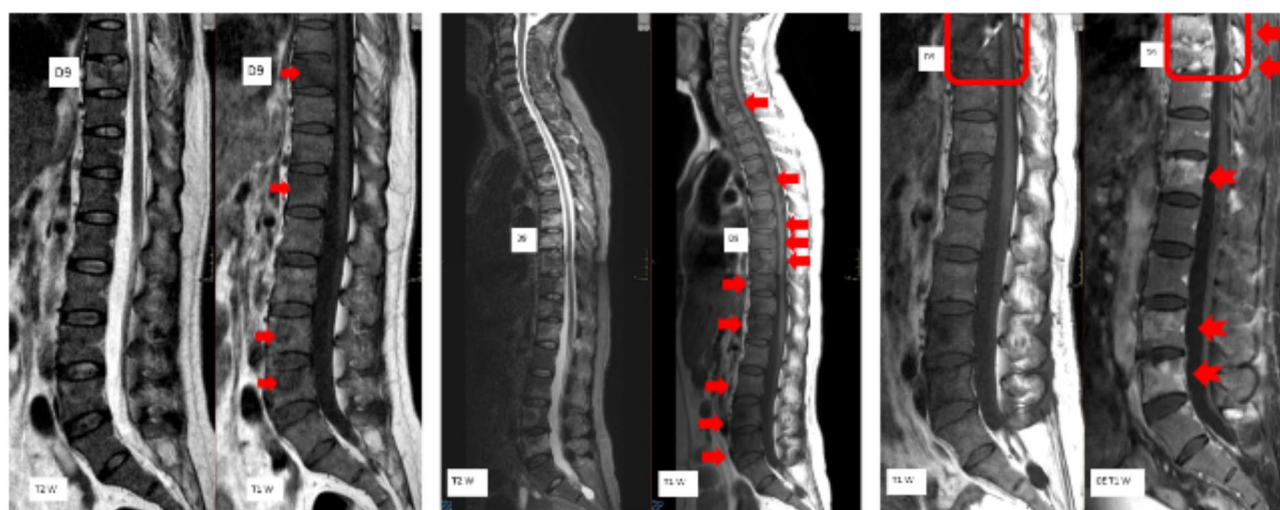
(A) MRI showing spinal involvement. (B) MRI showing progression of spinal involvement. (C) MRI showing skeletal disease progression in presence of paravertebral pathologic tissue surfacing in the epidural endorachis at D8-D9
